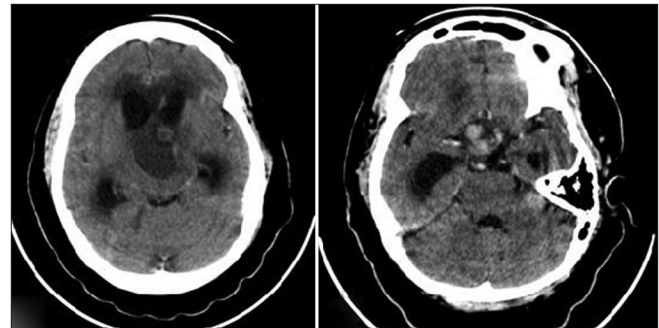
Pre-contrast- and post-contrast-enhanced CT of patient with breast cancer. Huge mixed density metastatic mass in the suprasellar region with resultant hydrocephalus
